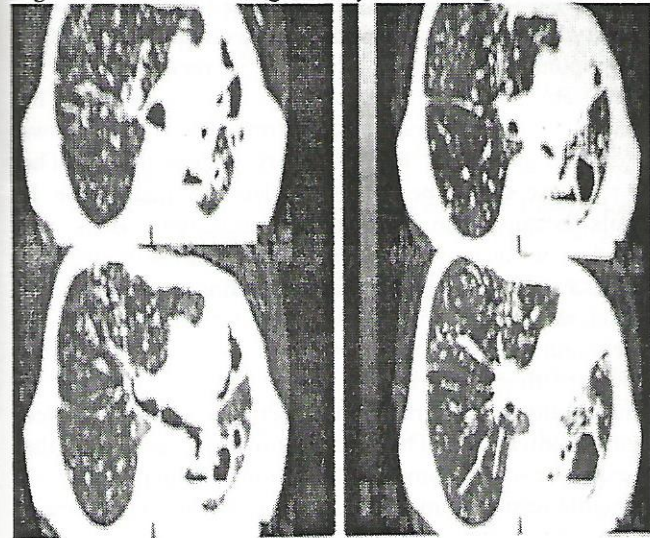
CT-Scan showing aspergilloma
